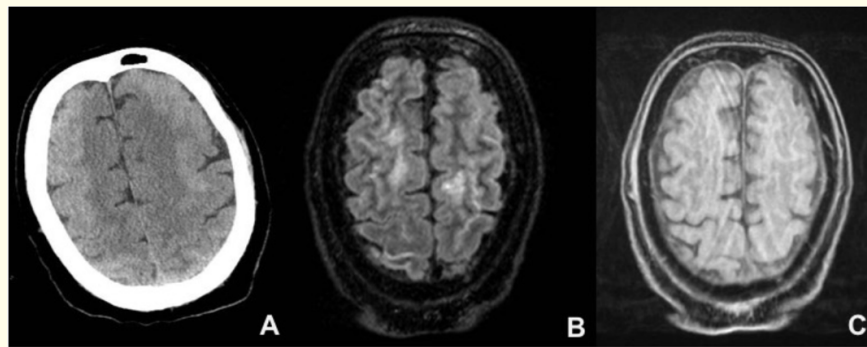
Neuroimaging. Figure 1A: CT scan. Figure 2B: MRI, axial FLAIR sequence. Figure 2C: MRI, post-gadolinium axial T1 sequence.
